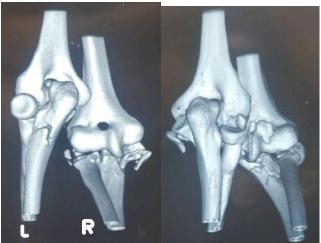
3D CT imaging of left and right elbows
